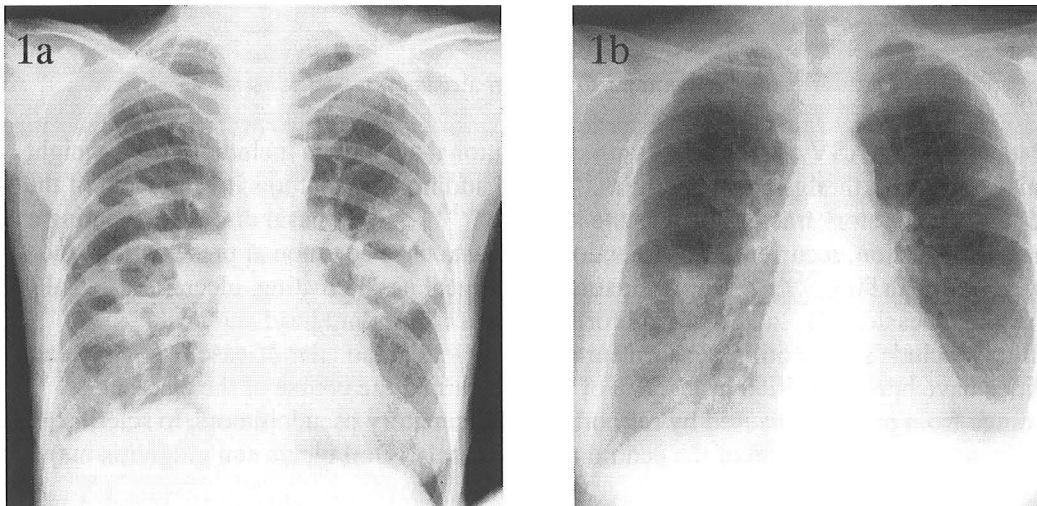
Typical plain film patterns in two subjects with Wegener's granulomatosis. Figure 1a demonstrates multiple, bilateral cavitating masses in a patient with chronic sinusitis, cough and hemoptysis. Figure 1b shows bilateral nodular opacities and a right lower lobe alveolar infiltrate. This patient had a history of epistaxis and dry cough, and presented with acute renal failure.
